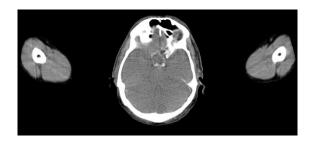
Brain CT scan, bone window- showing homogenous borders of the skull bones, without evidence of bone destruction, the usual pattern of meningioma.
